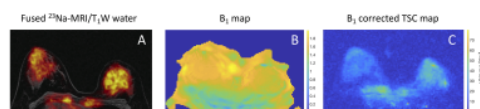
A) Fused ^{23}Na -MRI and T_1 -weighted water images, B) B_1 map and C) B_1 corrected tissue sodium concentration (TSC) map.
